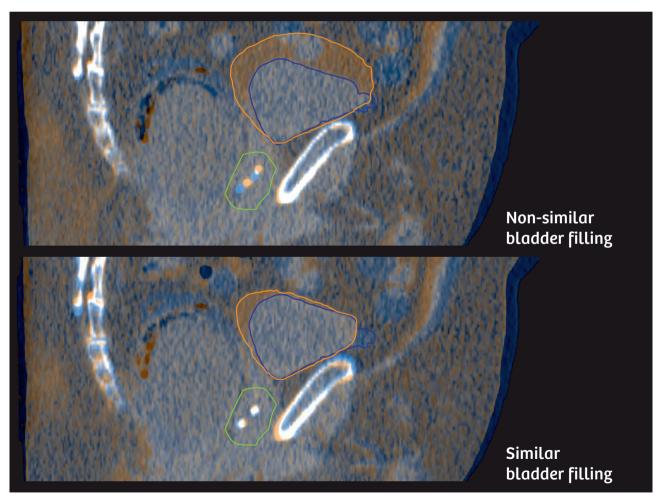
Example of inter-fractional variation in a prostate tumor patient for low-dose control CTs: overlay of planning CT (blue) and control CT (orange) – regions in grey do not differ between the two CTs. The bladder is contoured accordingly. In the top image the bladder volume was higher on the day of treatment compared to the planning CT, whereas in the bottom image the bladder filling was similar. The green contour highlights the marker position.
